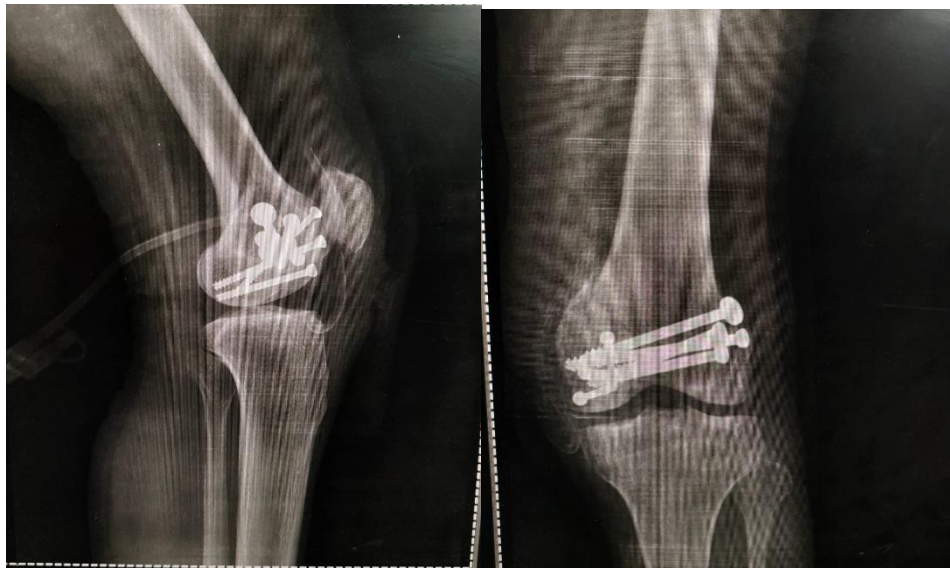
Post op xray of fixation of lateral Hoffa fracture by multiple cc screws
